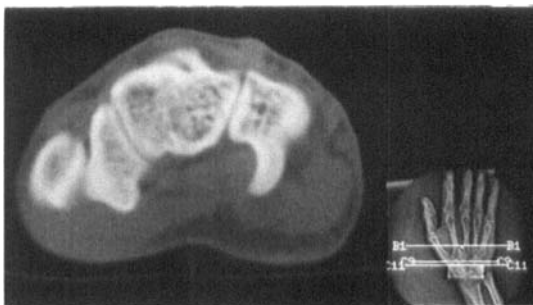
CT shows carpal bossing and fusion between the capitate and trapezoid bones. From left to right the structures shown are base of trapezium, fused trapezoid-capitate, and hamate.
